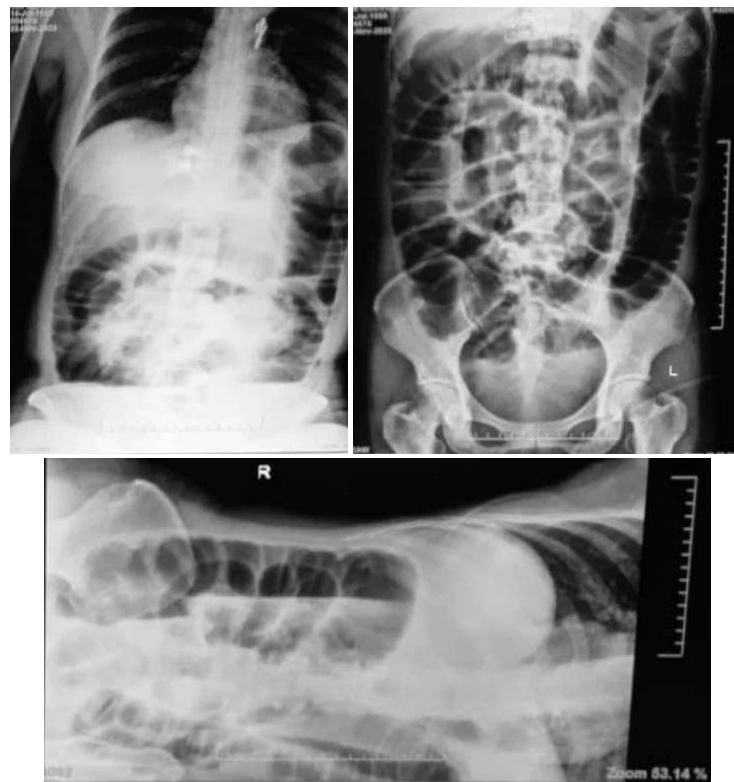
Plain abdominal x-rays
